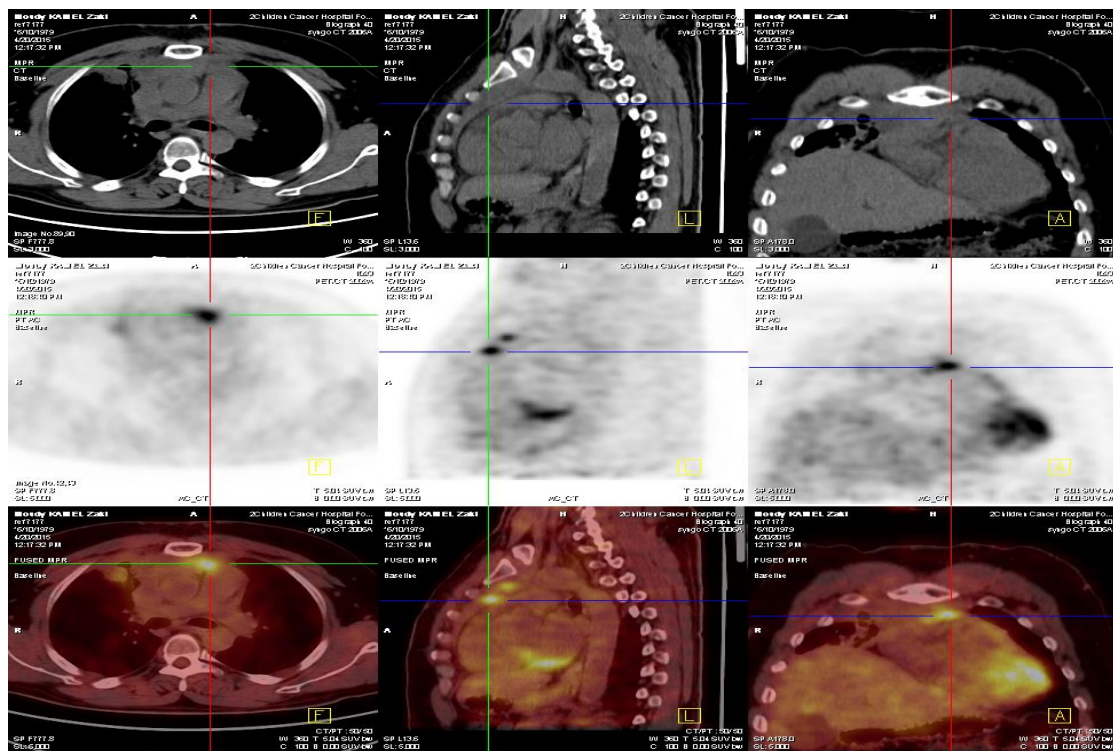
A): 35 yrs old male patient with NHL (large B cell), with large anterior mediastinal mass following treatment with residual viable FDG uptake in delayed scan with SUV of 5.
